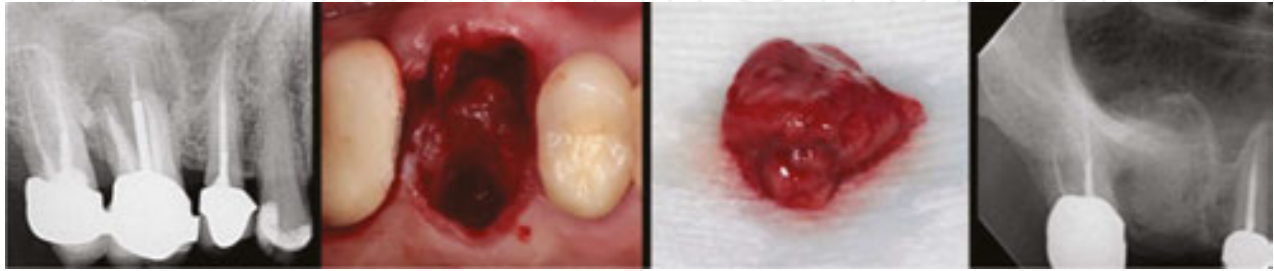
This molar has obvious trifurcation involvements and periapical infection. With the tooth removed, the granulations are apparent, considerably more than expected. When cleaned out, a large sinus perforation to the distal was apparent. There was no ability to stabilize an implant, so the procedure was changed to a “Socket Regeneration” procedure.
